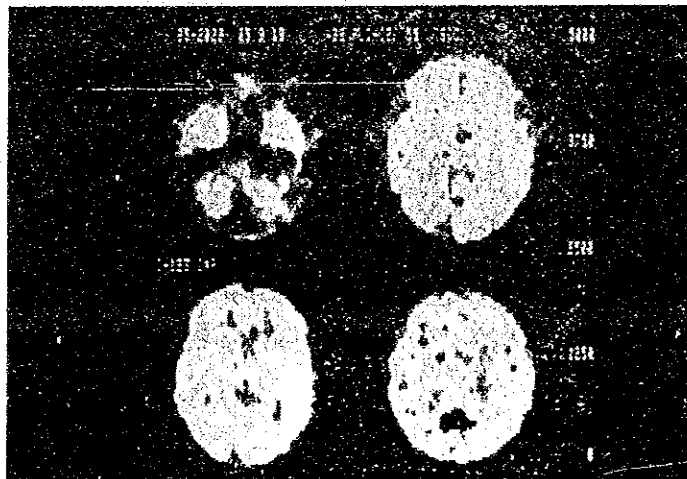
SPECT images using ^{123}I IMP
